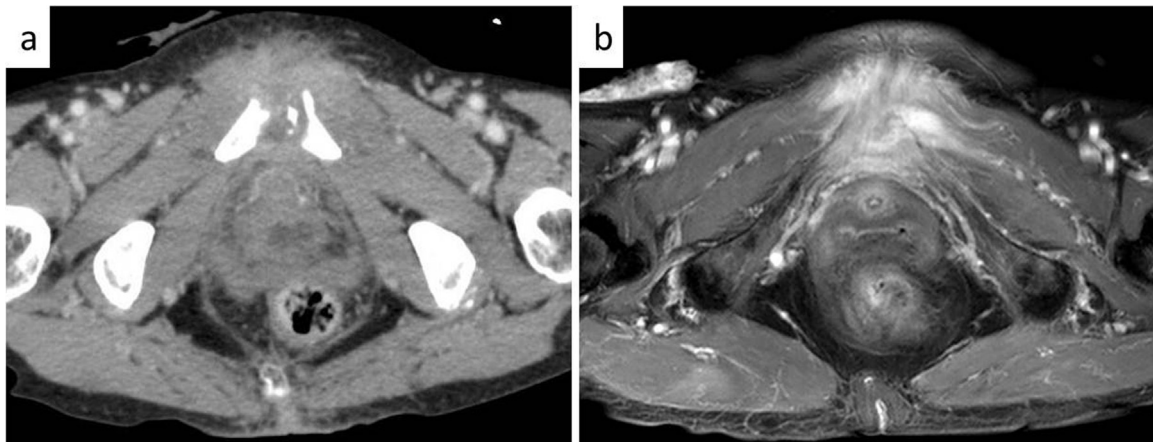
a. CT revealed that osteolysis and strong irregularity of pubic symphysis. b. MRI revealed that fistula and abscess extended to the back side of the pubic symphysis and fluid collection around the wound.
